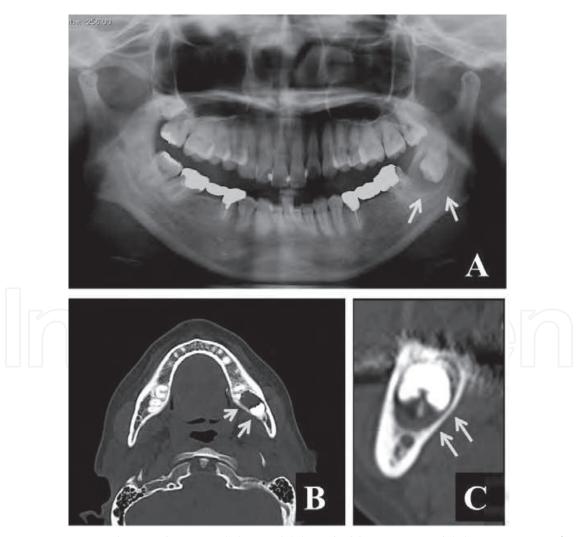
Panoramic radiograph image (A), axial (B) and oblique coronal (C) CT images of a dentigerous cyst in the left mandibular third molar region (arrows).
